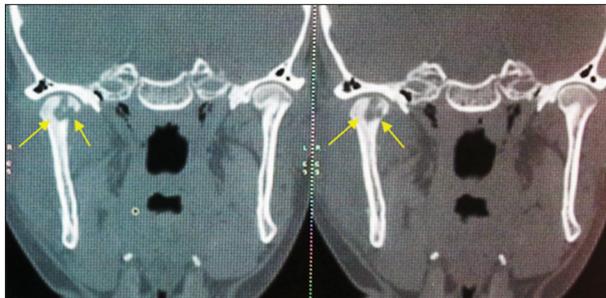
Computed tomography image of the head revealing the osseous destruction of the head of the right condyle
